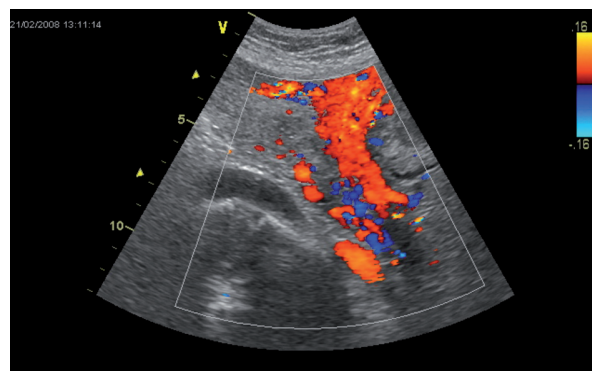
Colour Doppler ultrasound scan of the right iliac vessels: hypoechoic thrombus in the external iliac vein
